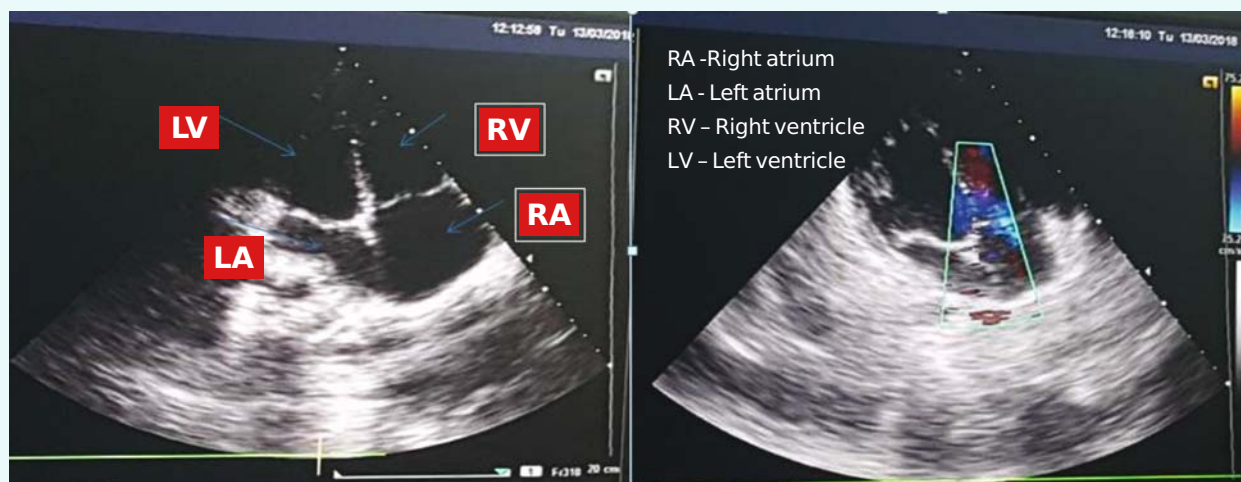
The echocardiography performed at the admission
